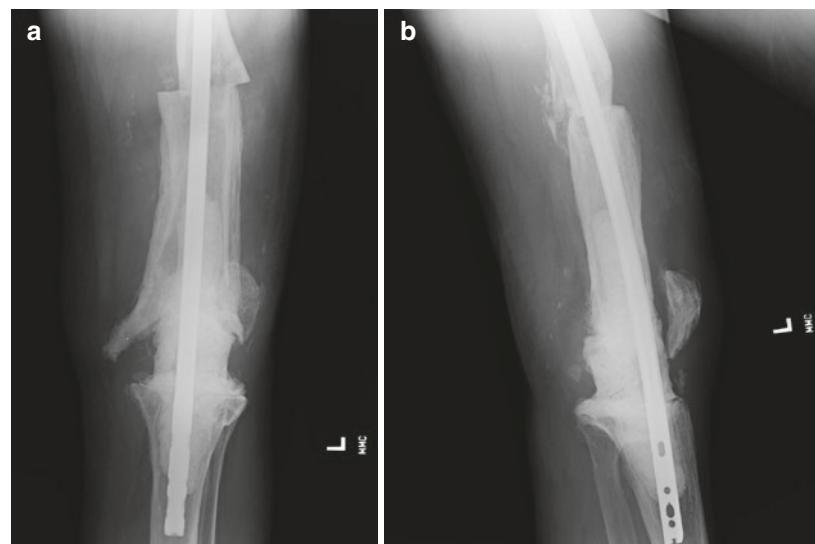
Postoperative anteroposterior (AP) (a) and lateral (b) radiographs showing the spacer to be in good position
